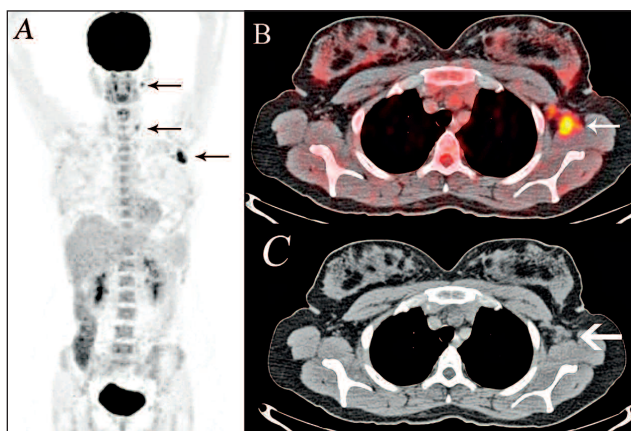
Maximum intensity projection (A), fusion (B) and CT (C) images of ^{18}F -FDG PET/CT showed increased ^{18}F -FDG uptake in the left cervical (in levels IIB and IV-V, maximum standardized uptake value (SUVmax), 4.6) and left axillary lymph nodes (SUVmax, 8) (arrows). Mild ^{18}F -FDG uptake in the right cervical region was considered as due to surgery involvement.
